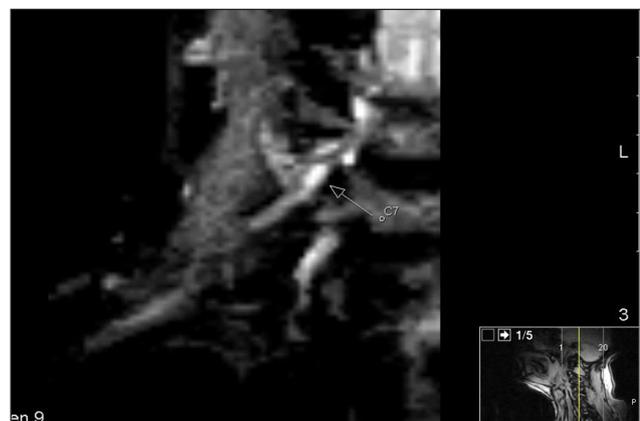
In coronal plane of STIR sequence MRI, increased in intensity and irregularity at right middle trunk level of brachial plexus are seen.
